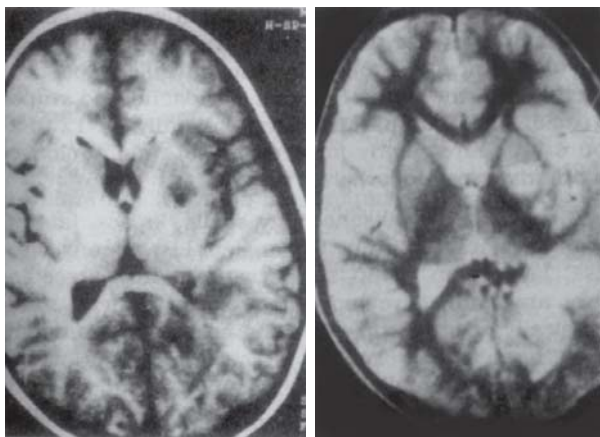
Neurocysticercosis MRI, T1- and T2-weighted axial images, showing degenerating parenchymal cysts.
